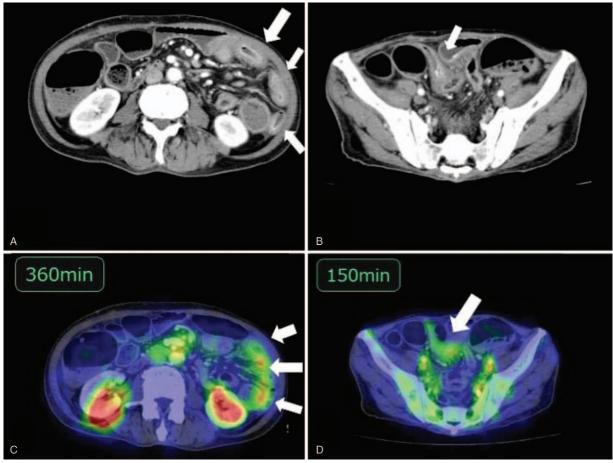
CT scan and 99m Tc-labeled human serum albumin scintigraphy findings. (A, B) CT scan revealed an enhanced hypertrophied wall of the short segment of small intestine (arrows). (C, D) 99m Tc-labeled human serum albumin scintigraphy revealed protein leakage into the wall thickened small intestine (arrows).
